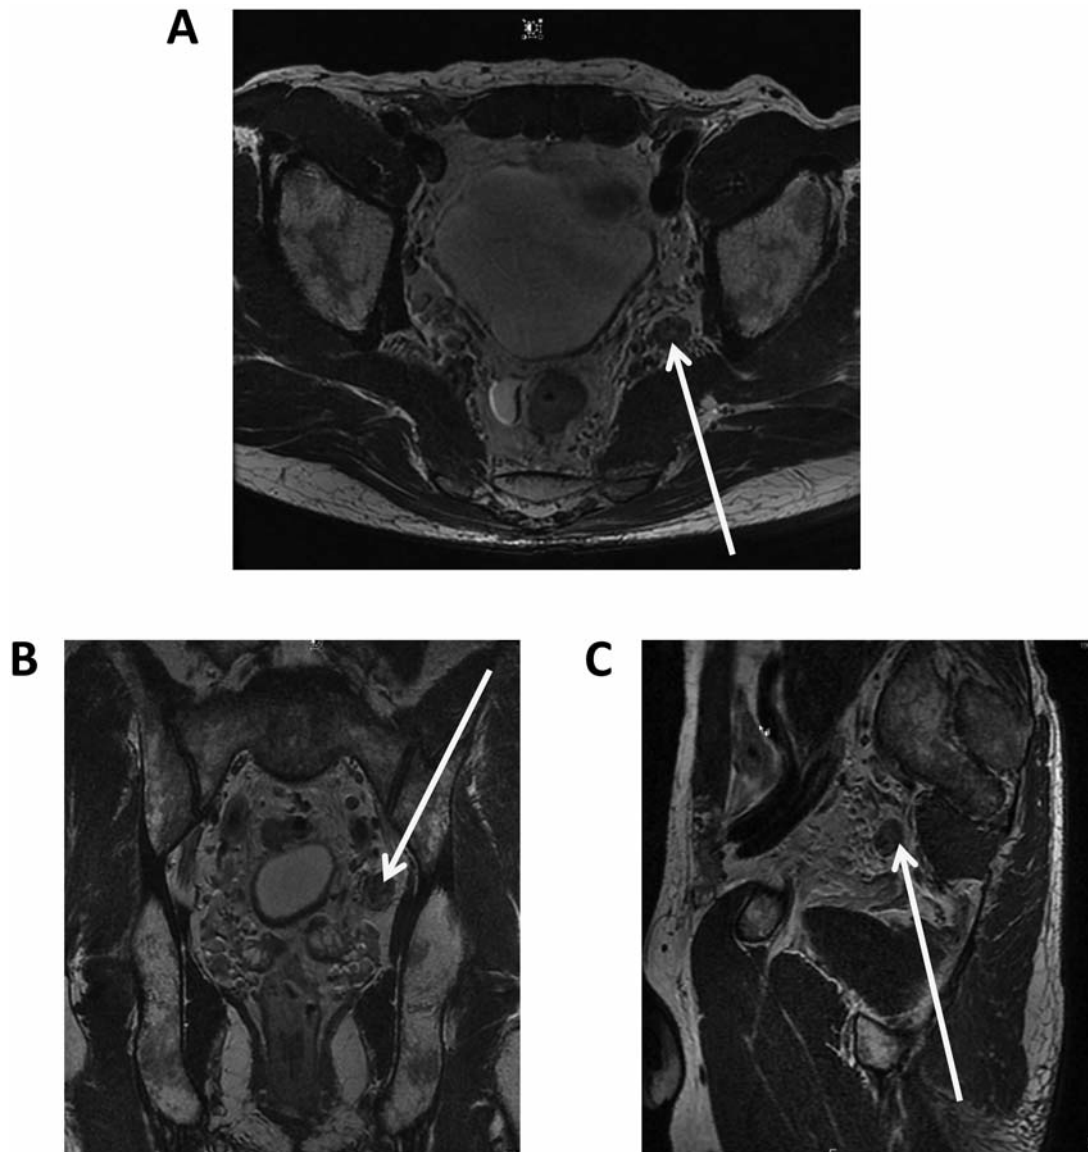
Typical magnetic resonance imaging findings of a clearly swollen lateral lymph node. The lymph node was located in the left internal iliac area, and in this case, extended pelvic lymph nodes were dissected. A: T2-weighted high-resolution axial image; B: T2-weighted high-resolution coronal image; C: T2-weighted high-resolution sagittal image.
